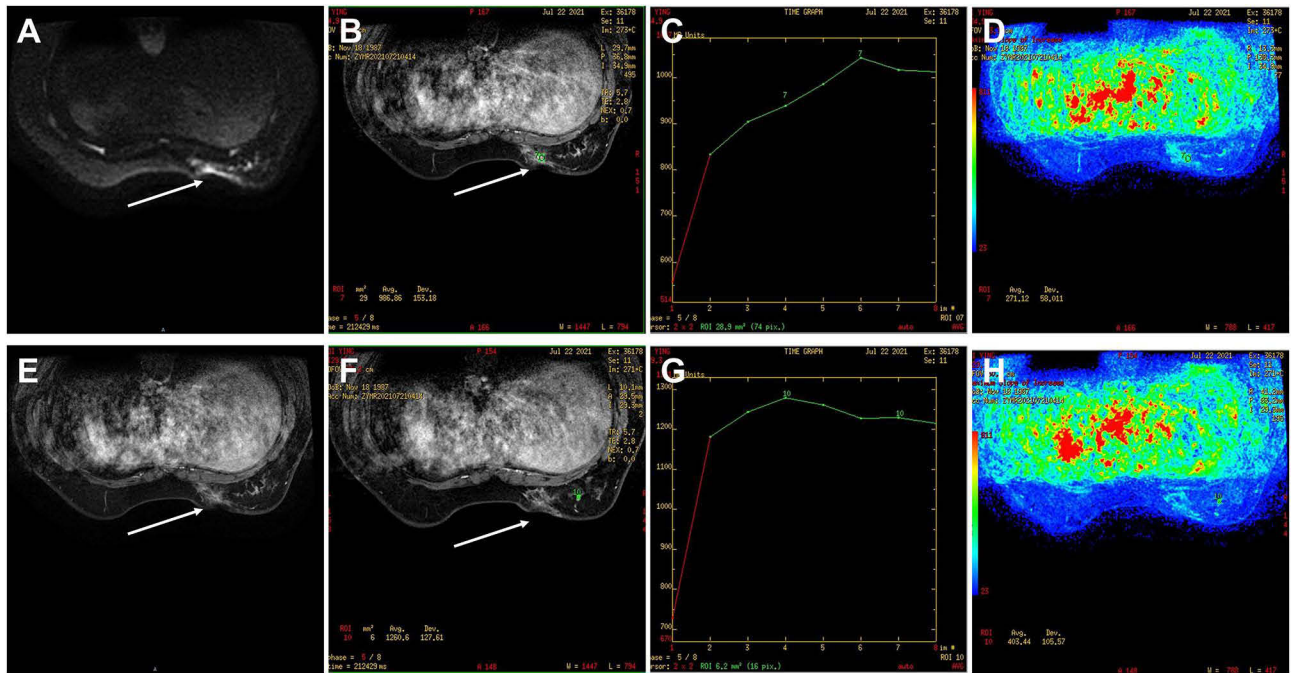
Breast MRI after lesion excision in July 2021.
